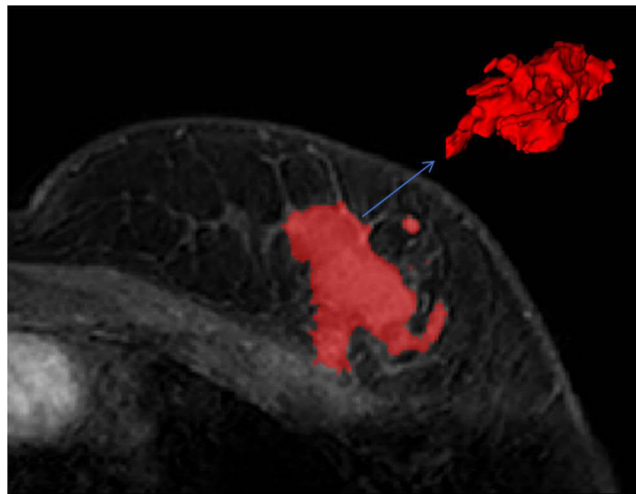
DCE-MRI image of a 52-year-old female patient with an irregular mass in the upper outer quadrant of the left breast, showing a washout enhancement curve in dynamic contrast-enhanced imaging. The blue arrow indicates the breast tumor lesion/region of interest delineated on DCE-MRI.
